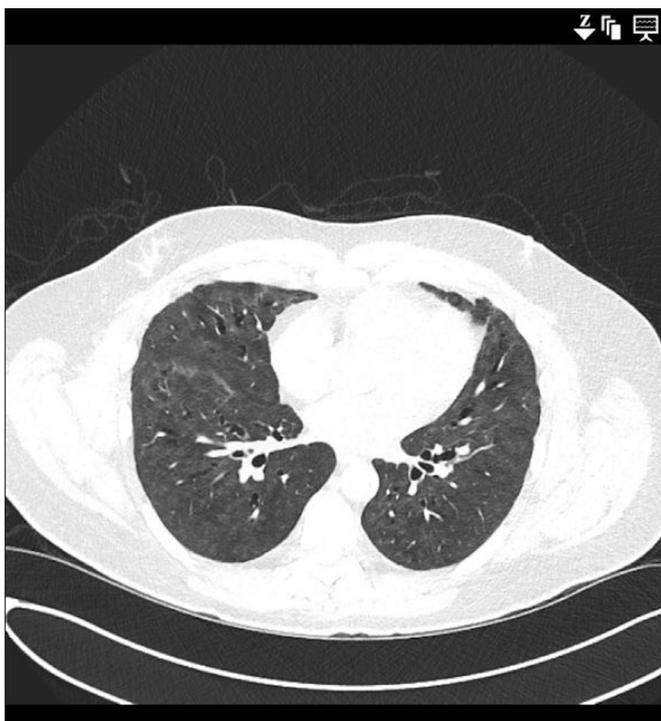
Most recent CT scan of the patient's chest showing resolved acute respiratory distress syndrome and pneumonia, basilar view.
